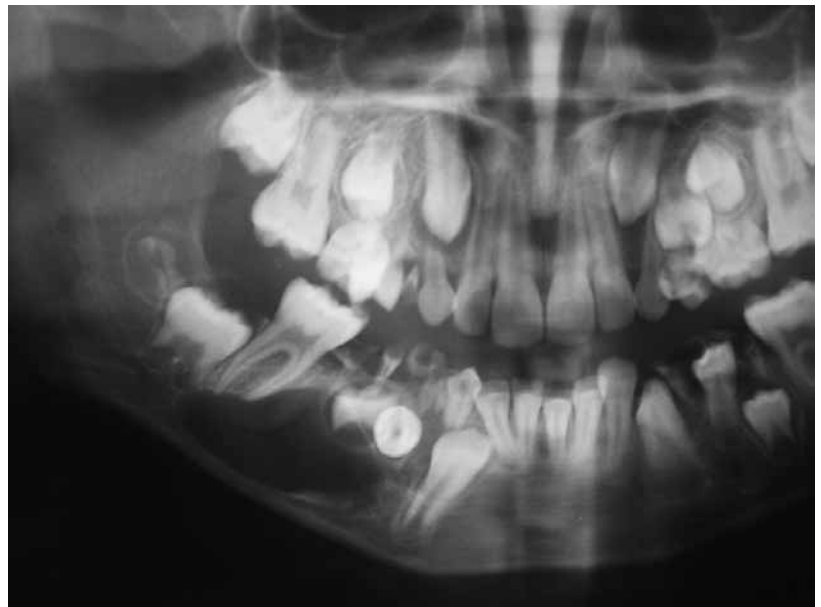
Panoramic Xray showing a large radiolucency with a marked radio-opaque rim in the right mandible which displaced the 4.4 and 4.5 tooth buds.
